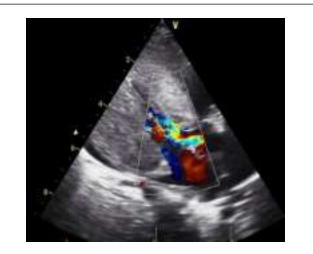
Doppler Echocardiogram showing maximal left ventricular (LV) wall thickness of 11 mm with complete mid cavity systolic obliteration and impaired LV relaxation.
